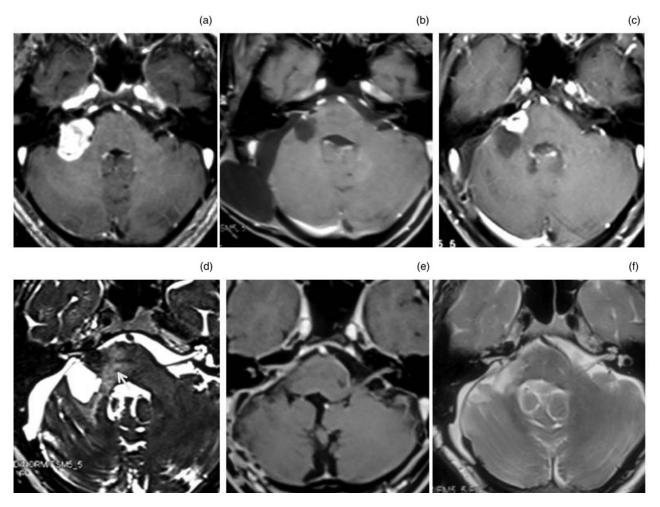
Axial magnetic resonance imaging (MRI) of case 4. (a) Pre-operative T1-weighted MRI post-contrast image showing a homogeneously enhancing right vestibular schwannoma. (b) Post-operative T1-weighted MRI post-contrast image six months later showing no abnormal enhancement or tumour residue. (c) Post-operative T1-weighted MRI post-contrast image one year later showing an area of enhancement in the cerebellopontine angle cistern. (d) T2-weighted MRI sequence done at same time showing the oedema within the brain stem (white arrow). The patient was asymptomatic at this time and underwent re-exploration and removal of granulation tissue at this time. The cultures were sterile. (e) T1-weighted MRI post-contrast image six months later demonstrating resolution of the lesion and (f) resolution of the oedema on T2-weighted MRI sequences.
